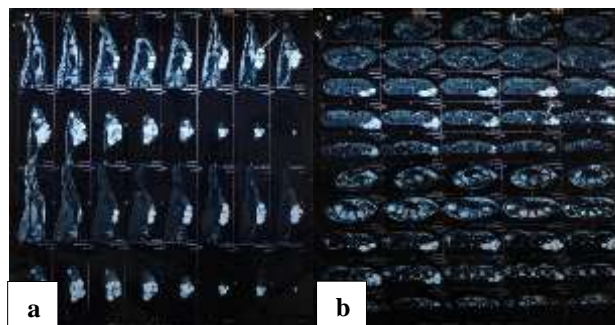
(a and b): MRI finding displaying extent of soft tissue involvement.
